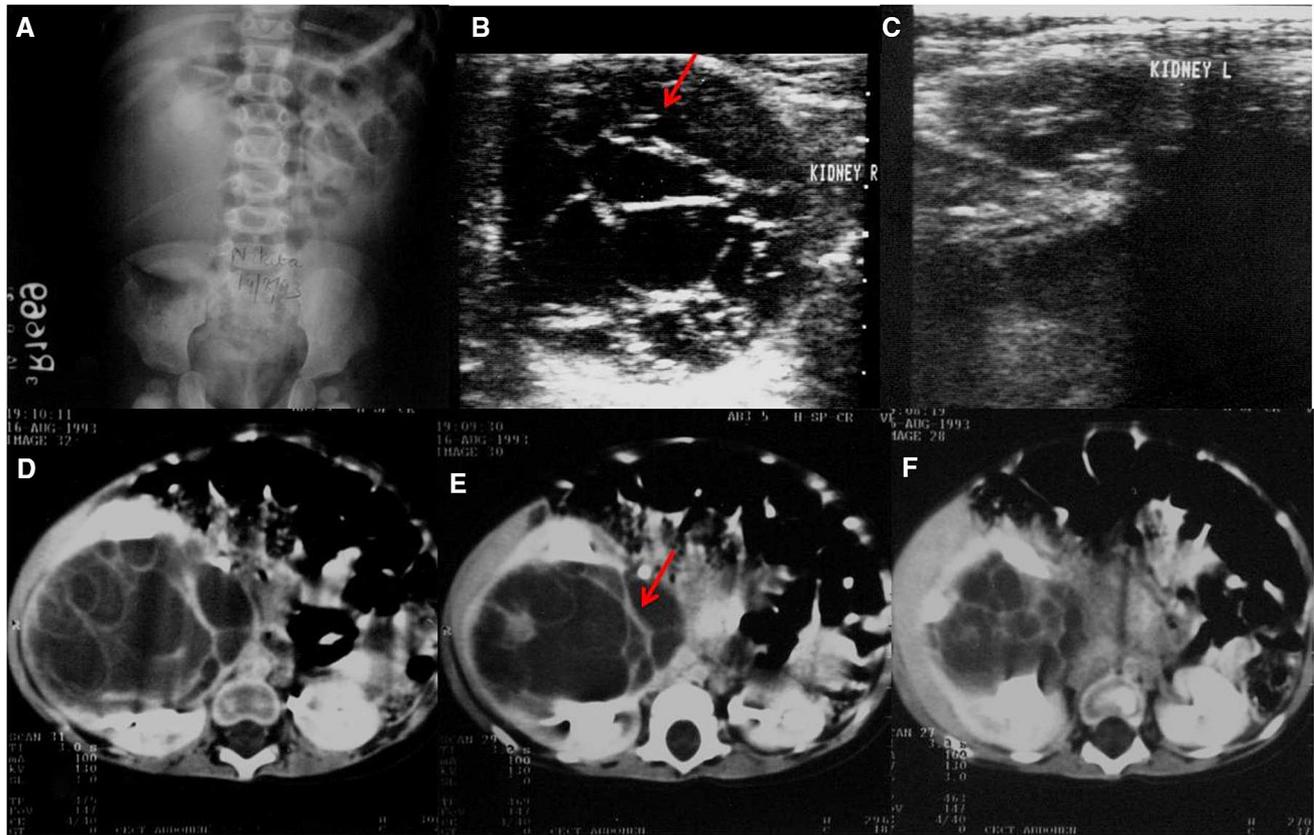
A–F A girl of 8 months was brought with a palpable mass in the right renal angle. Radiograph of abdomen (A) showed a large right-sided retroperitoneal mass. Ultrasound right kidney (B) revealed a large multiloculated cystic mass with multiple septa (red arrow) replacing almost
